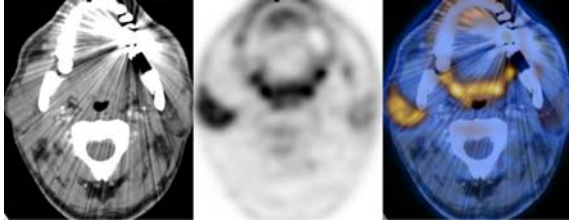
Asymmetrical FDG uptake at the salivary gland in patient with a history of left buccal cancer treated with surgery and radiation therapy. FDG uptake at the right salivary gland is a normal finding. Relatively decreased uptake at the left salivary gland from prior radiation therapy is observed
